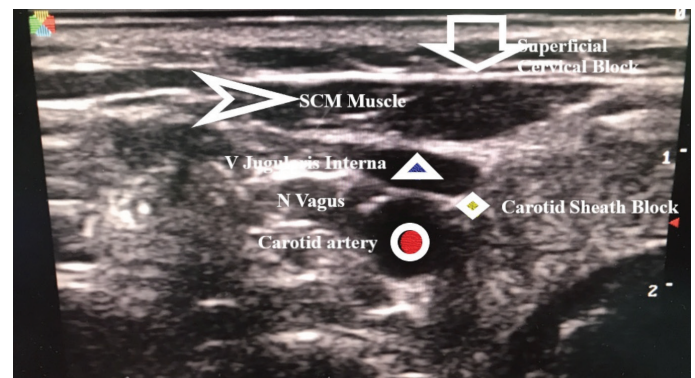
Ultrasonographic anatomic landmarks for superficial cervical plexus block and carotid sheath block
